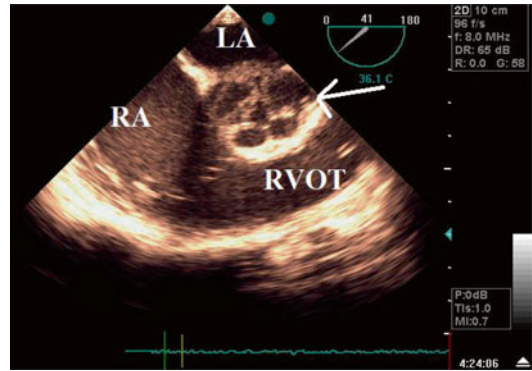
Quadricuspid aortic valve in short-axis transesophageal echocardiography associated with significant aortic regurgitation
